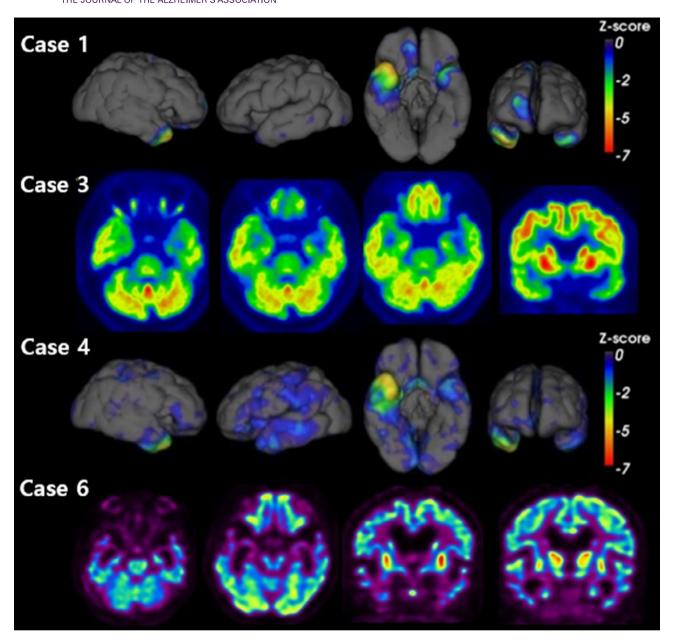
¹⁸F-FDG-PET images. ¹⁸F-FDG-PET images revealed decreased glucose metabolism in the bilateral anterior temporal areas, worse on the right side (case 1, 4, 6) or the left side (case 3). The images of Case 1 and Case 4 were obtained from the Australian e-Health Research Centre (https://aehrc.csiro.au/wileyonlinelibrary.com]). The images were quantified and correlated with a 3D surface image using CapAIBL (https://milxcloud.csiro.au/wileyonlinelibrary.com]). To quantify uptake in PET images, focal uptake values were divided by those of the cerebellum (reference region). After quantification, a z-score map was created on the 3D surface image. The images of Case 1 were reprinted with permission from the European Journal of Neurology 2022;29:3124-3126. ¹¹ 18F-FDG-PET, [18F]-fluoro-2-deoxy-D-glucose positron emission tomography; 3D, three-dimensional; PET, positron emission tomography.
